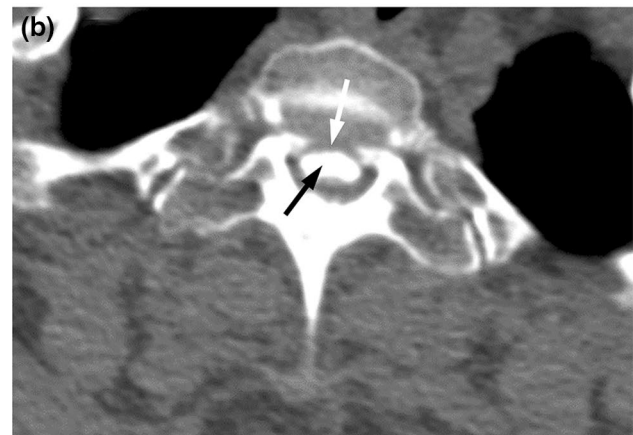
CT scan of thoracic disk herniation with posterior longitudinal ligament ossification (THDO). 2(a) Sagittal CT and 2(b) axial CT, the white arrow indicates the herniated disk, and the black arrow indicates the ossified posterior longitudinal ligament
